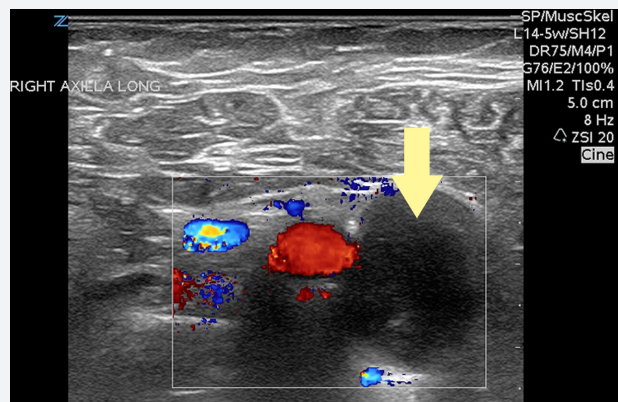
Transverse high sensitivity color Doppler image through the lesion fails to demonstrate internal blood flow ruling out pseudoaneurysm.
